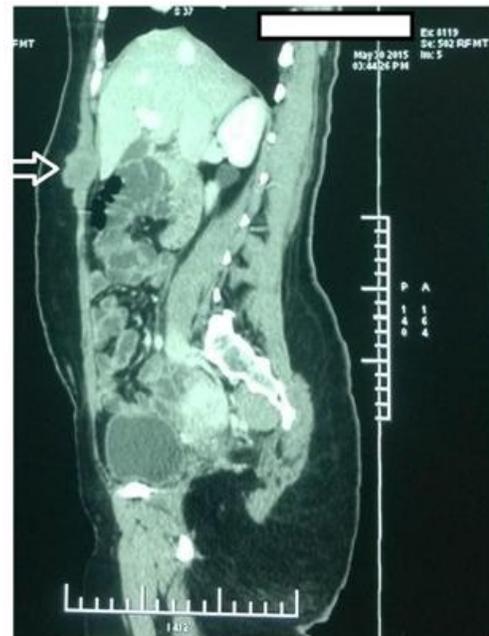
MRI shows the tumor's location embedded in the adjacent musculature. Arrow shows a hypo intense part of the tumour indicating the high mucoid proportion.
